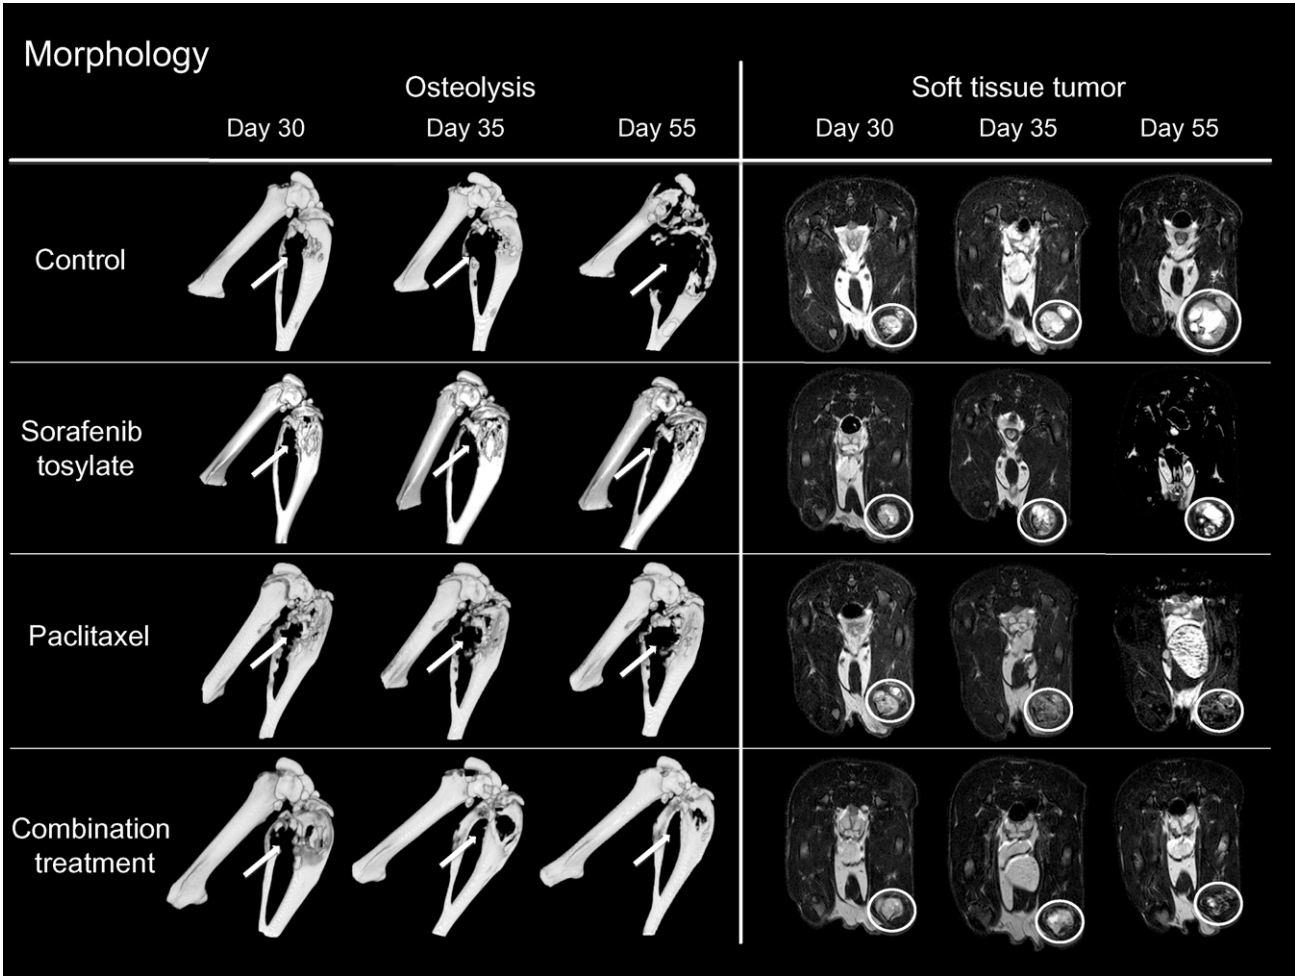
Morphology of bone metastases as imaged with VCT and MRI on days 30, 35 and 55 after tumour cell inoculation. Left side: 3D surface reconstructions from VCT images (white arrows indicating osteolyses within bones of the right hind leg). Right side: axial slices from T2-weighted MRI through the largest diameter of the hyperintense soft tissue tumour (delineated by white circles in each row).
